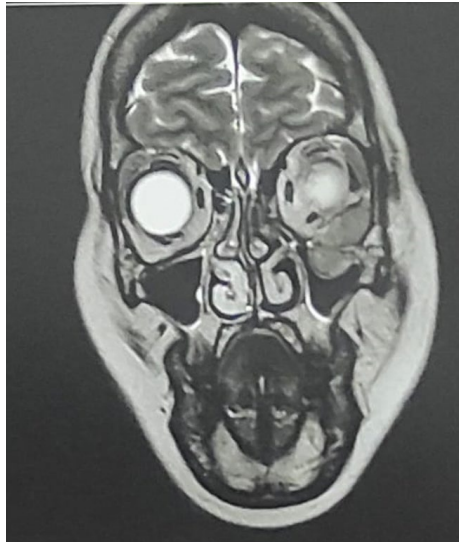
MRI coronal sections showing a hypo-isointense mass in the left infratemporal fossa on T1 and T2 weighted images, extending to the maxillary sinus and the lateral and inferior walls of the left orbit.
